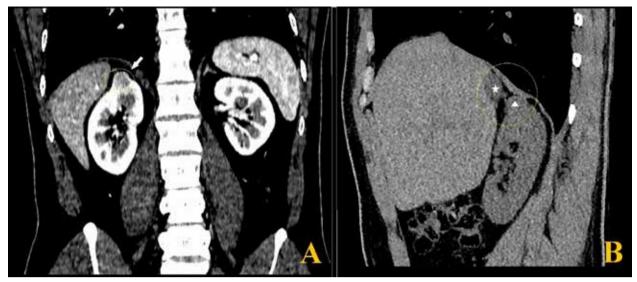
(Abdominal CT examination): A 2 cm mass in the upper pole of the right kidney (arrow) revealed in contrast-enhanced CT (A). In contrast-unenhanced CT, the same kidney mass (arrowhead) and adrenal mass adjacent to the liver (star) are seen together (B).
